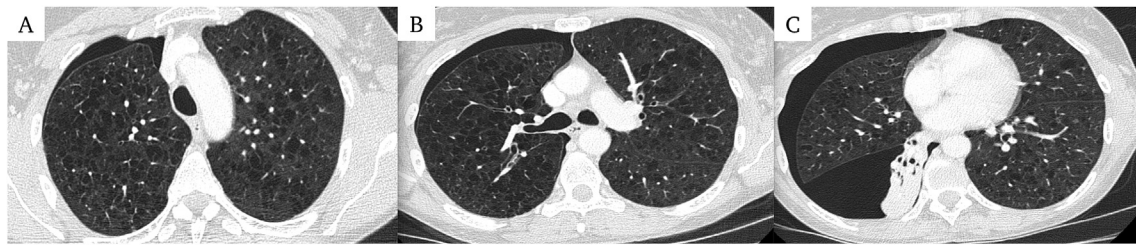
Non-contrasted computed tomography of the chest in lung window and transverse plane demonstrating centrilobular emphysema and innumerable, diffuse cysts of variable sizes in upper (A), middle (B), and lower (C) lung zones.
